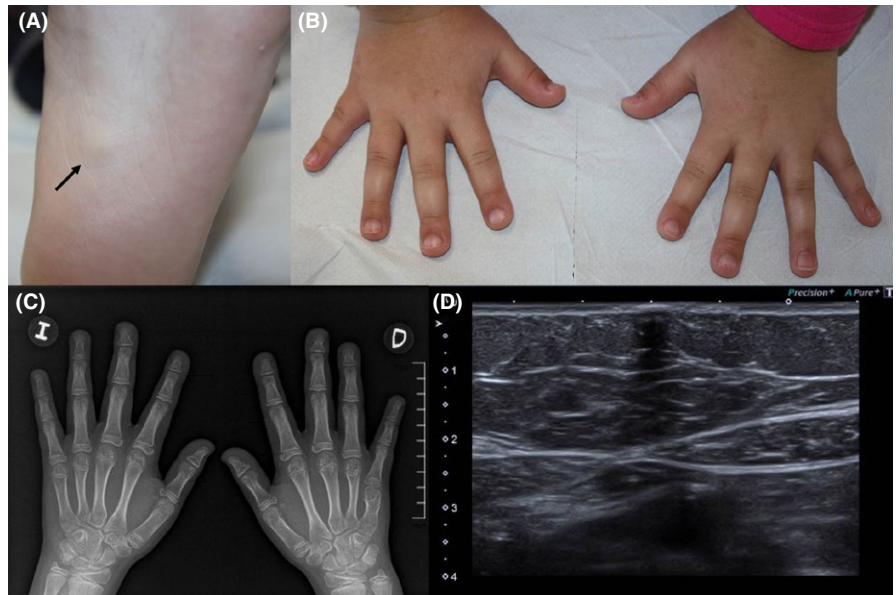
Clinical, radiological, and ultrasound findings in patient 2. (A) Hard nodule on patient's left sole (arrow). (B) Bilateral shortening of fifth fingers. (C) Radiography, where right fifth metacarpal shortening and left fifth metacarpal hypoplasia are visible. (D) Ultrasound of nodule on left sole, showing hyperechoic structures at dermo-hypodermis level with posterior acoustic shadowing
